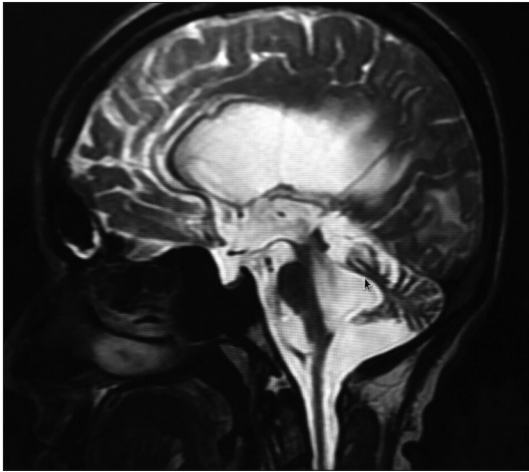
MRI T2W sagittal image showing diffuse atrophy of cerebrum, cerebellum, and brain stem. Ventricles are widely dilated secondary to brain atrophy, and bulging and thinned corpus callosum
